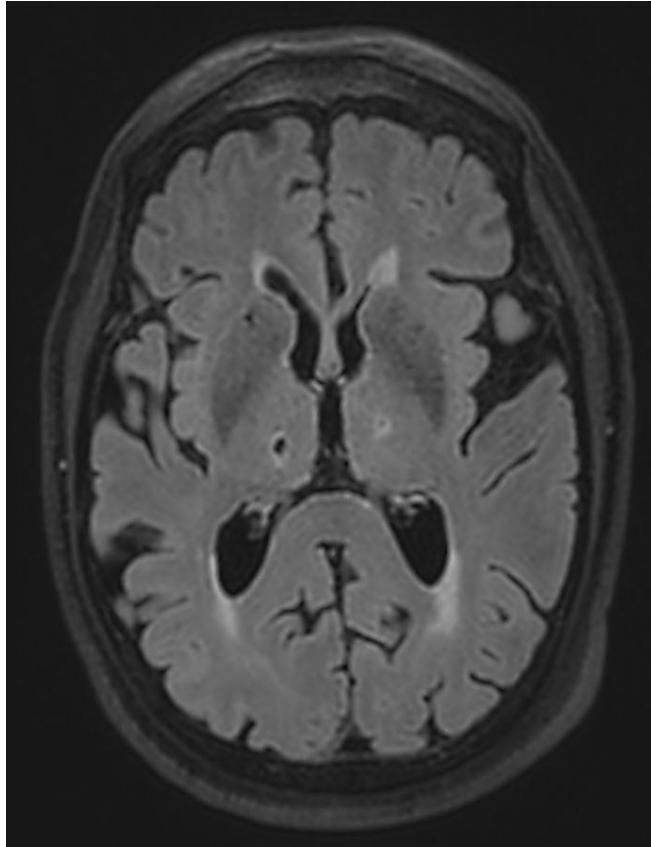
Bilateral hyperintense lesions in both thalami on a FLAIR sequence.
